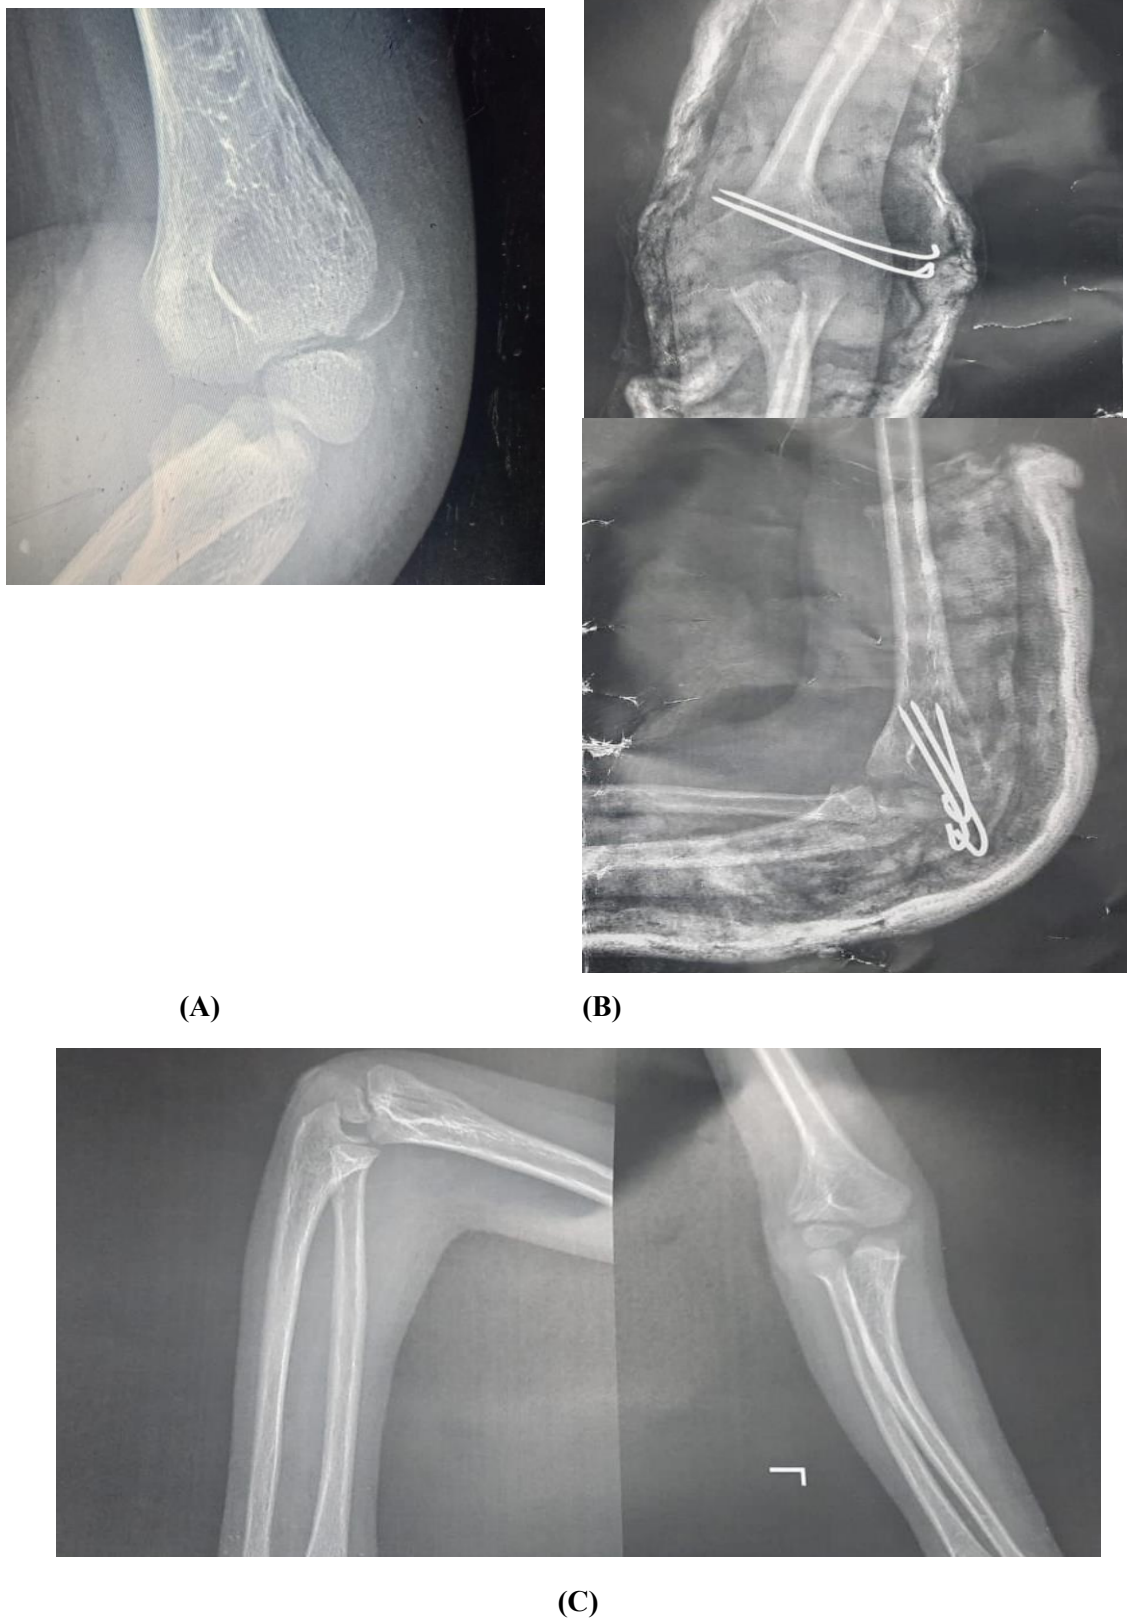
A 4 year old male managed using k-wires (A): Pre-operative x-ray., (B): follow up x ray after 4 weeks (C): Follow up x-ray after 6 weeks
